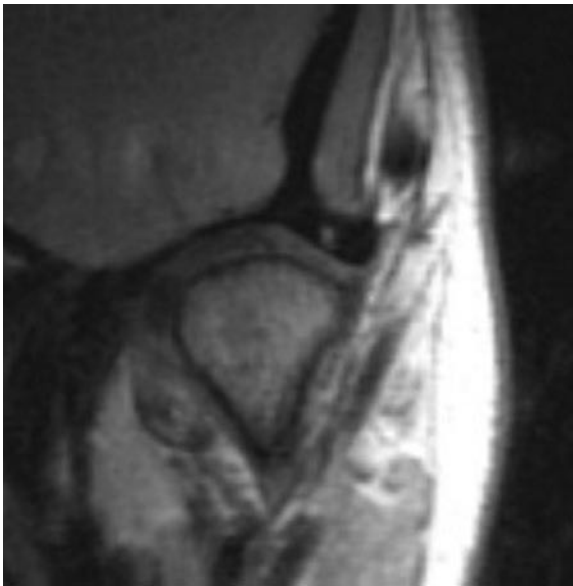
MR imaging, PD-sequence of the temporo-mandibular joint during occlusion in the frontal plane. Medial disc displacement (<).
